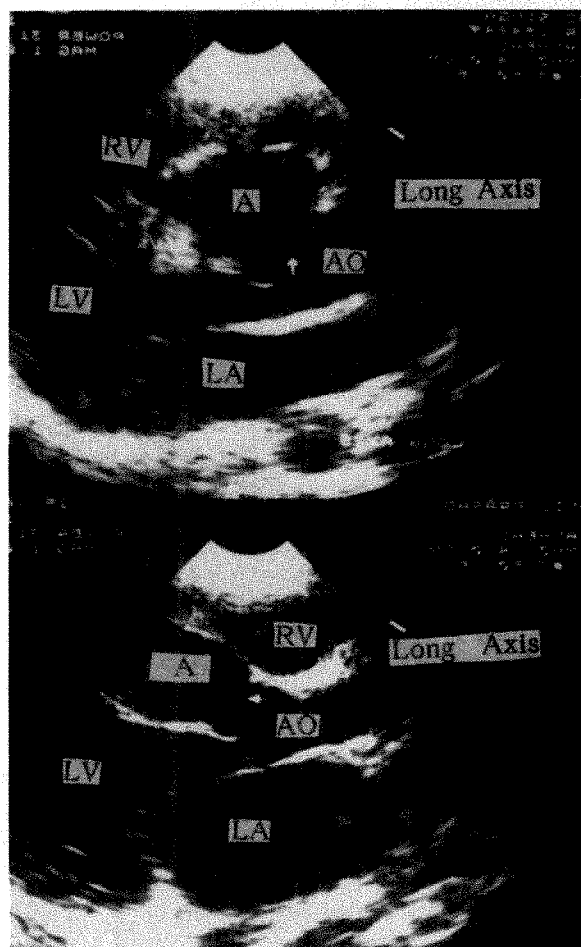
Two-dimensional echocardiography. Long-axis views of the 2 patients showing sinus of Valsalva aneurysms (A) dissecting into the upper part of interventricular septum. AO = aorta; RV = right ventricular; LV = left ventricular.
